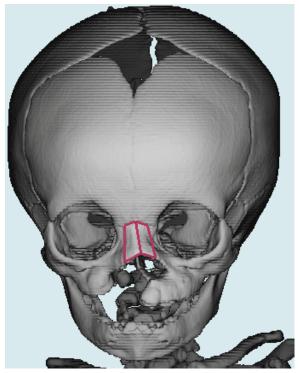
Frontal view of three-dimensional computed tomography image of nasal bone "wire frame".
